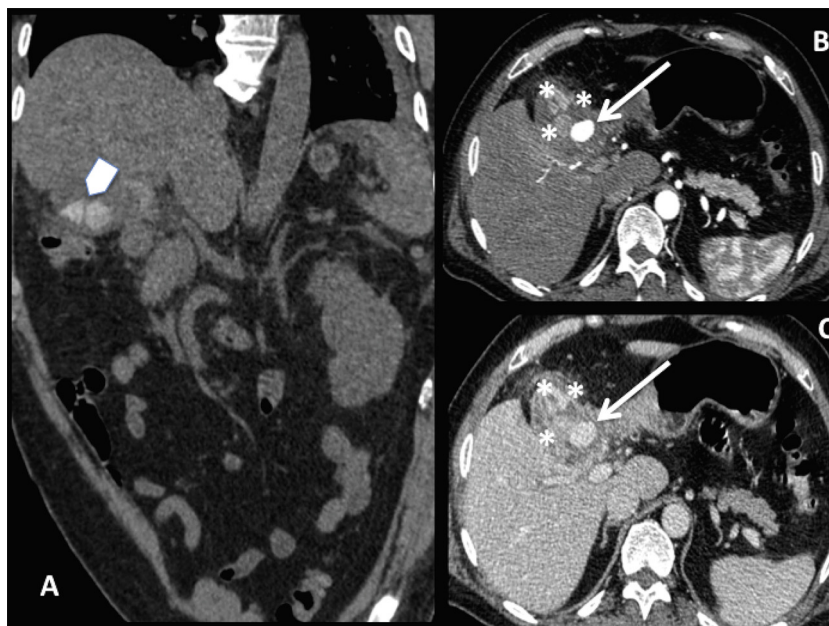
CT examination: coronal pre-contrast image (A); axial arterial (B) and portal (C) phase images. Arrowhead in A shows some large gallstones. After administration of the contrast medium the pseudoaneurysm appeared inside the gallbladder as a round mass with the same density of the arteries (arrows in B e C). Thick and irregular cholecystic walls with inhomogeneous perivisceral fat (asterisks in B e C) suggested us the hypothesis of cholecystitis.
